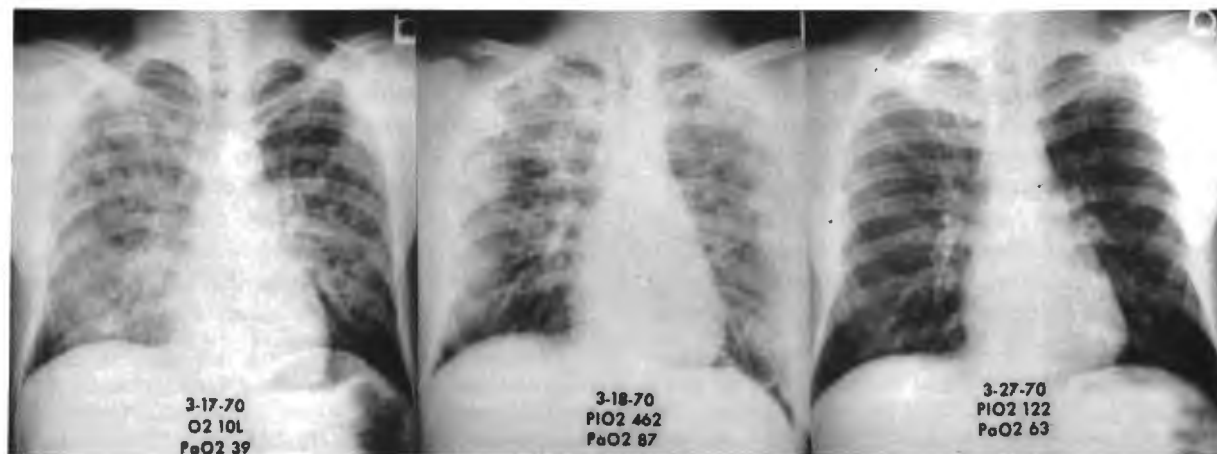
(left)—Chest roentgenograms on admission. Note oxygen liter flow with concomitant arterial oxygen tensions (Case 1). Fig. 2 (center)—X-ray clearing on second hospital day. High inspired oxygen tension (462) required for adequate arterial oxygenation (Case 1). Fig. 3 (right)—Further x-ray clearing and near normal oxygen transport (Case 1).
